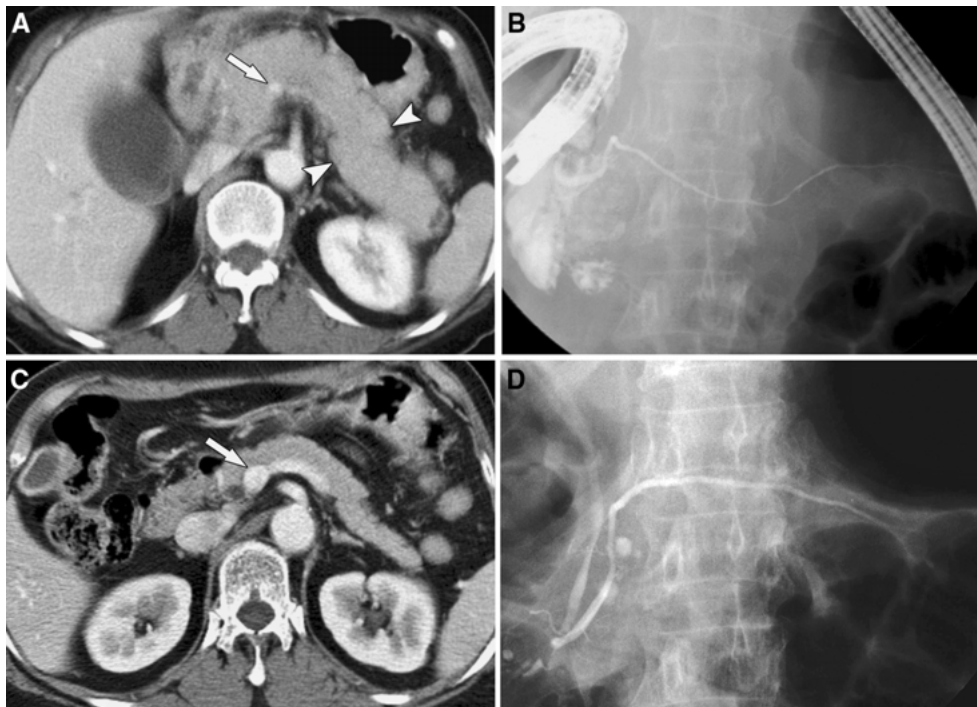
AIP in a 65-year-old woman that presented as epigastric pain for 4 months. A Contrast-enhanced CT image shows diffuse enlargement of the pancreas (*arrowheads*). Narrowing of the portal confluence portion (*arrow*) is noted. B ERCP image shows diffuse narrowing of the main pancreatic duct throughout the entire pancreas. C On contrast-enhanced CT obtained 2 months after steroid therapy, enlargement of the pancreas has decreased. Narrowing of the portal confluence (*arrow*) has also decreased. D On ERCP images obtained 2 months after steroid therapy, diffuse narrowing of the main pancreatic duct has decreased.
